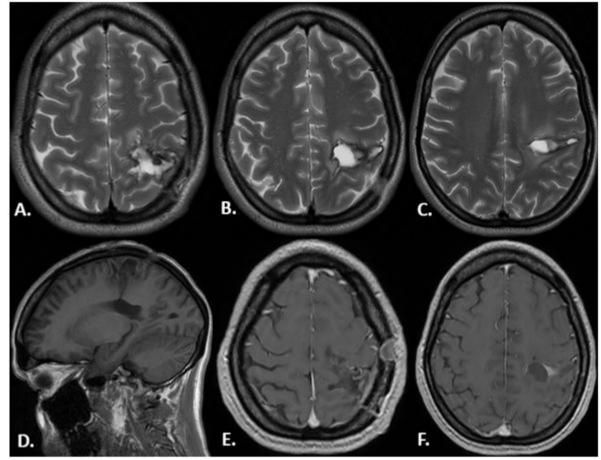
A, B, C: Axial T2-weighted images. D: Sagittal T1-weighted image. E, F: Axial T1-weighted images with contrast enhancement. The 3-mmonth follow up MRI showed no residual AVM nidus being present. Post-operative and post-hemorrhagic changes at the site of the previously bled and embolized AVM can be observed.
